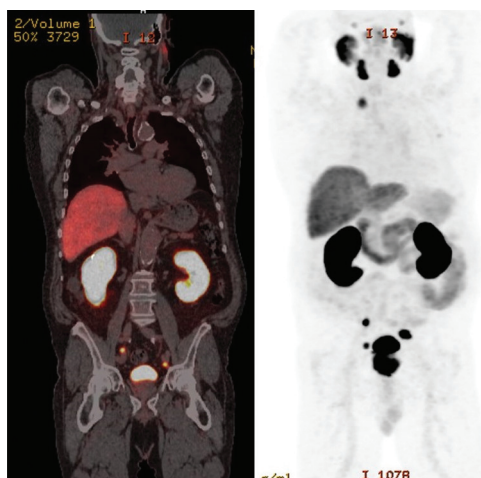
Comparison of ⁶⁸Ga-PSMA PET/CT (left) and ⁶⁸Ga-PSMA-PET (right) scans for staging prostate cancer. The images demonstrate high diagnostic accuracy in identifying primary lesions, lymph node involvement, and distant metastases, aiding in TNM staging and treatment planning.
